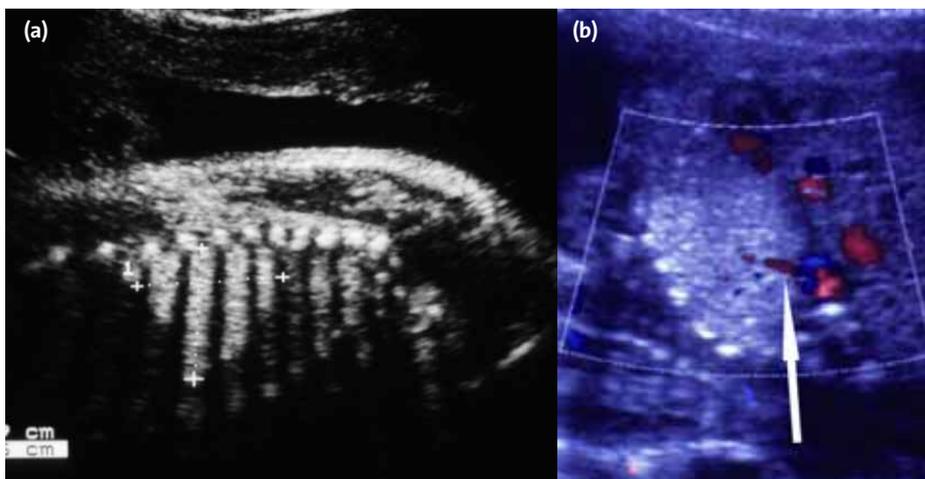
Fetal ultrasound showing a pulmonary sequestration (a). Doppler images clearly demonstrate the feeding vessel (arrow) (b).
